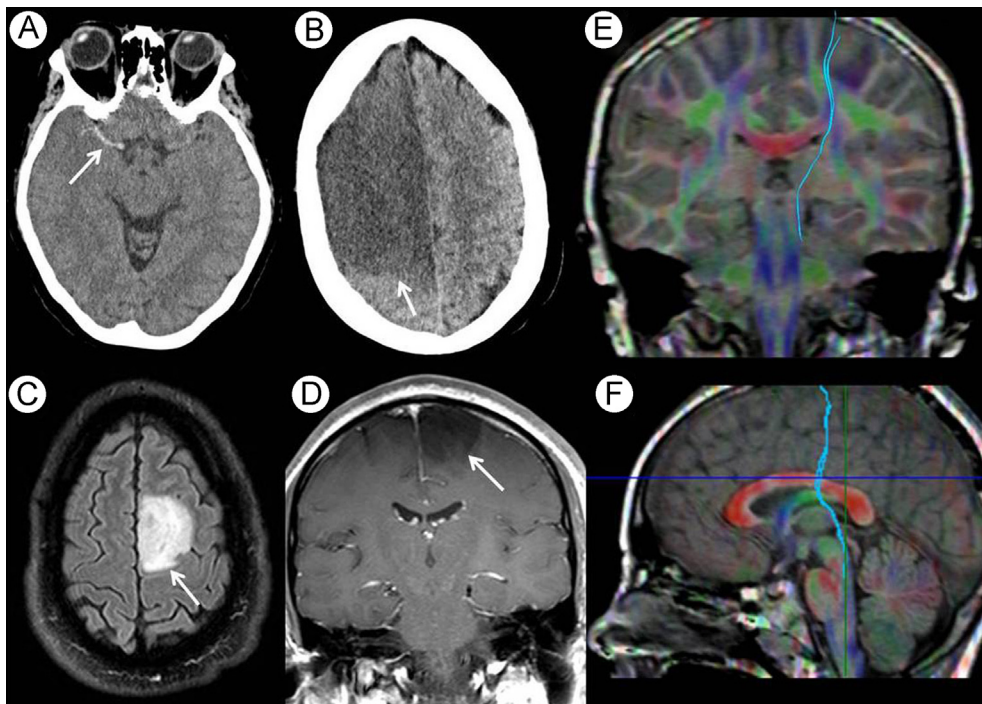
Frontal eye fields. (A and B) Axial CT in a patient with right distal ICA occlusion and total right anterior circulatory infarction. There is a hyperdense right MCA (arrow, A), the eyes are deviated toward the side of the abnormality and there is extensive superior frontal infarction including the right frontal eye fields (arrow, B). (C) Axial FLAIR and (D) coronal T1 postcontrast images of a left superior frontal grade II astrocytoma (arrows, C and D). The patient presented with seizures with fixed rightward gaze due to hyperactivity in the contralateral frontal eye field. (E and F) Tractography acquired by placing regions of interest in the frontal eye fields and tectal plate (superimposed on fused color FA map-T1 volume) showing fibers passing from the frontal eye fields, through the pulvinar, to the tectal region. CT, computed tomography; FA, fractional anisotropy; FLAIR, fluid-attenuated inversion recovery; ICA, internal carotid artery; MCA, middle cerebral artery.
